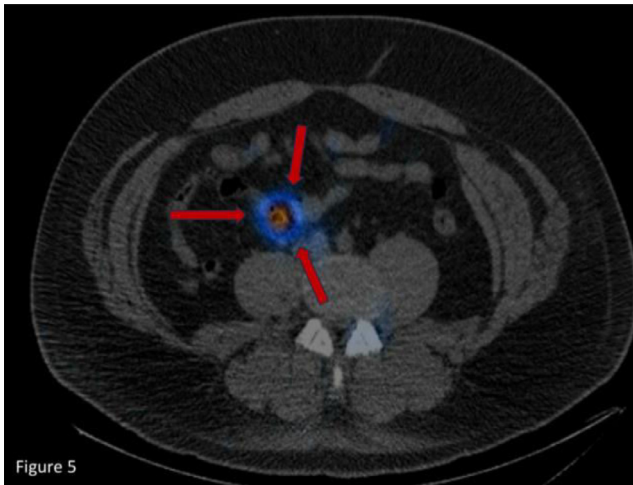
SPECT-CT was obtained (representative axial slice), localizing the area of abnormal pertechnetate uptake to the blind-ending structure described on CT, confirming the diagnosis of a MD.
